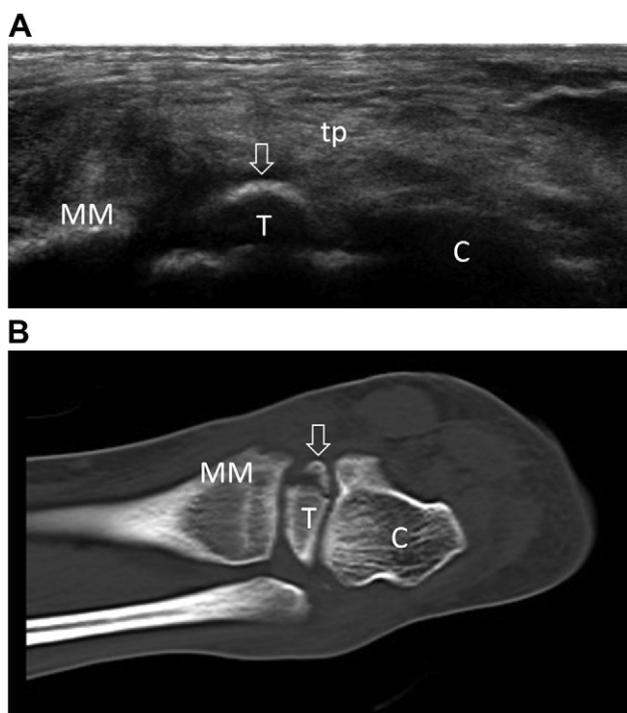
Sonography and computed tomography scan from a 26-year-old woman 2 months after an ankle sprain. Initial roentgenogram reports were negative. The ankle persisted to be painful and swollen in spite of vigorous physical therapy and medication. (A) Ultrasound picture of medial ankle shows an echogenic loose body (open arrow) between posterior tibialis tendon (tp) and talus (T). (B) Fracture of the postero-medial corner of talus (arrow) is confirmed by CT. The calcaneal bone (C) and medial malleolus (MM) are intact.
